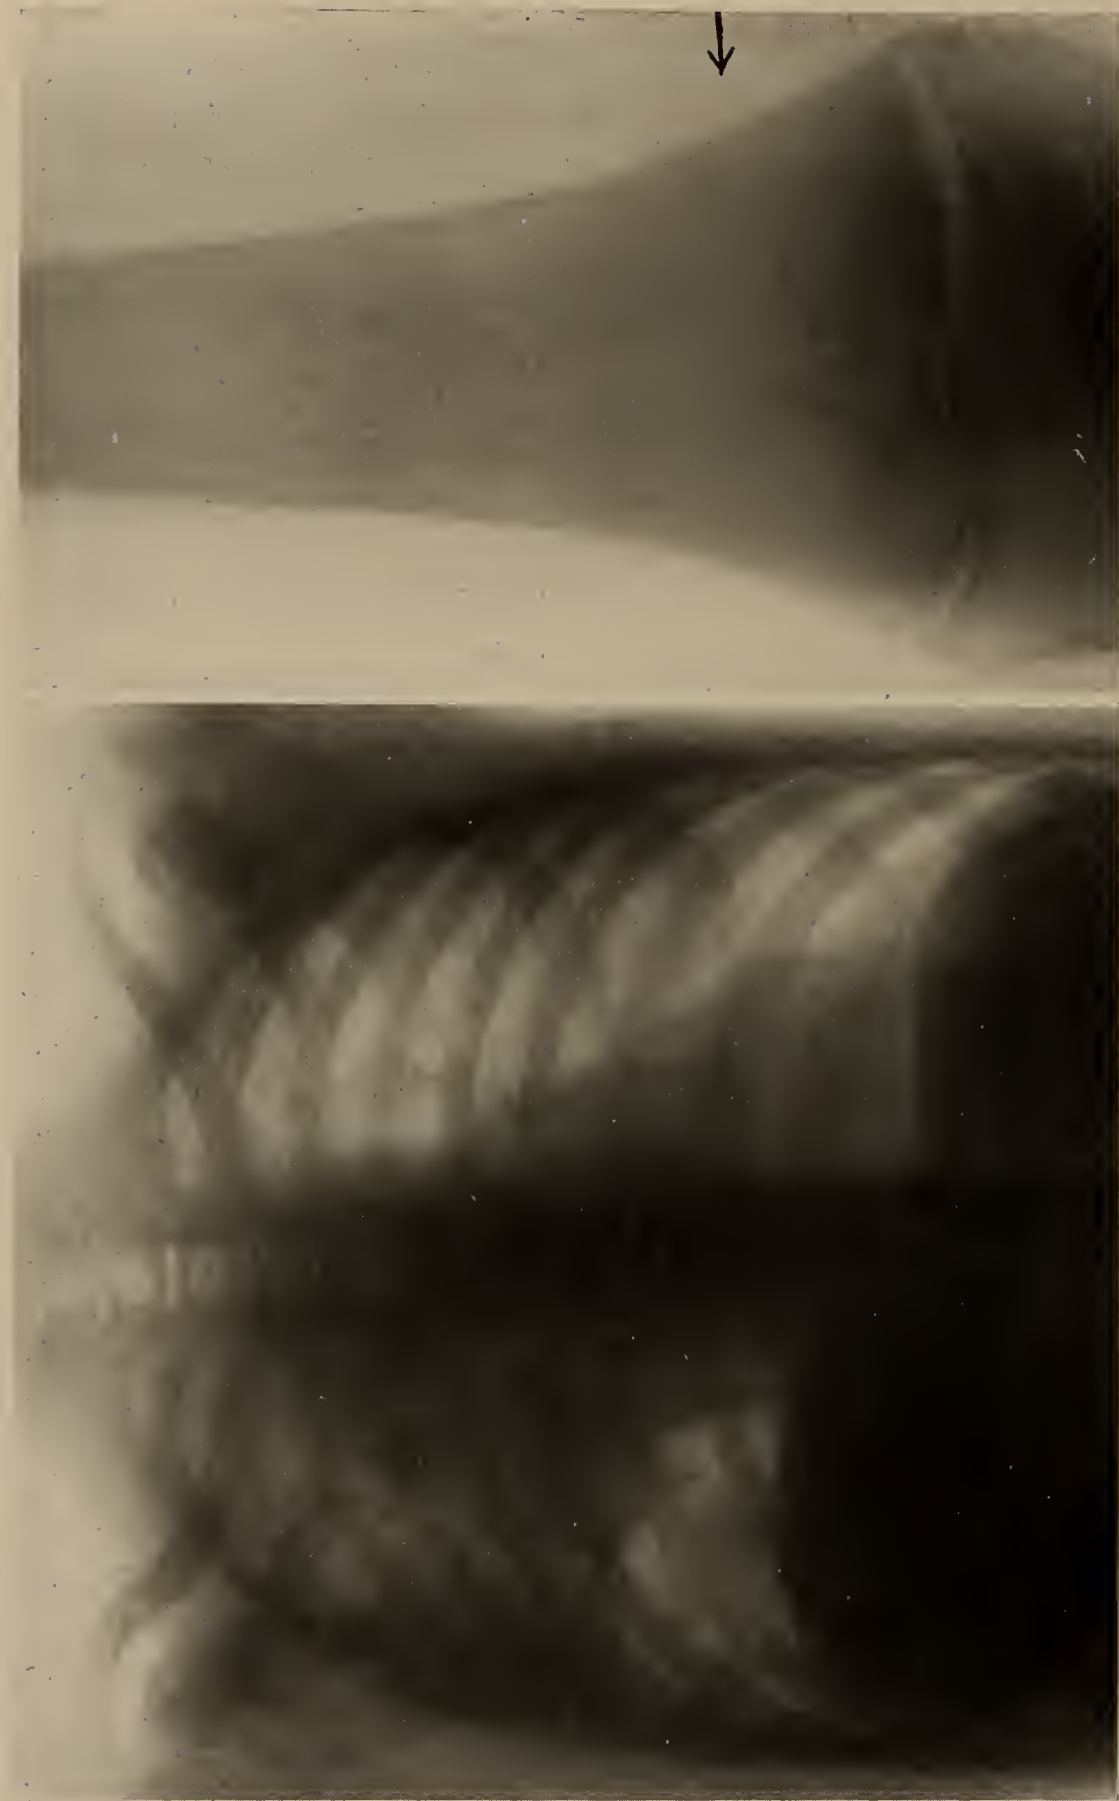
Courtesy of Dr. Baker, Newark; not registered. Osteogenic sarcoma in a boy 16 years old. The roentgenogram was taken 2 weeks after the clinical onset of the disease. Very little is to be seen in the roentgenogram except for a slight jaggling of the internal aspect of the femur (arrow). A roentgenogram of the chest made on the same day revealed far advanced pulmonary metastases.
